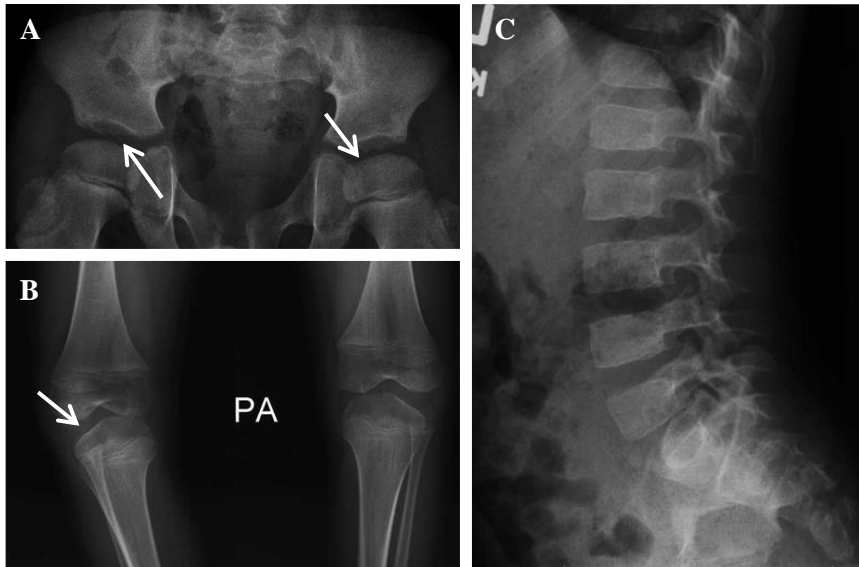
Radiographs of Patients Affected with Stickler Syndrome. Radiographs from a patient with a homozygous recessive mutation in *COL9A3*. A. AP hip showing mildly flat capital femoral epiphyses (left arrow) with irregularly-shaped acetabulae (right arrow). B) AP knee shows irregularly shaped proximal tibial epiphyses. C) No significant abnormalities observed in the lateral spine.
